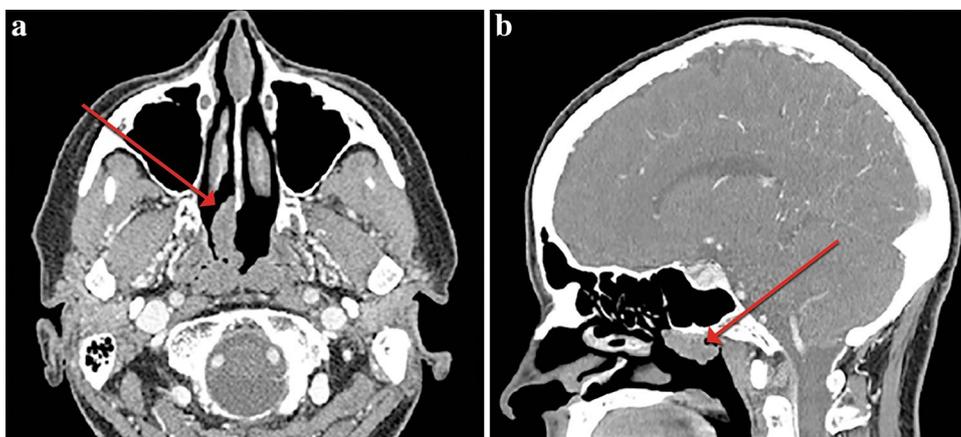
Contrast-enhanced axial (a) and sagittal (b) images in soft tissue window CT reveal a lobulated mass (red arrows) arising from the right posterior nasal septum and extending posteriorly into the right nasopharynx that is similar in attenuation to muscle (“isodense”) and hypovascular, without any significant contrast enhancement
